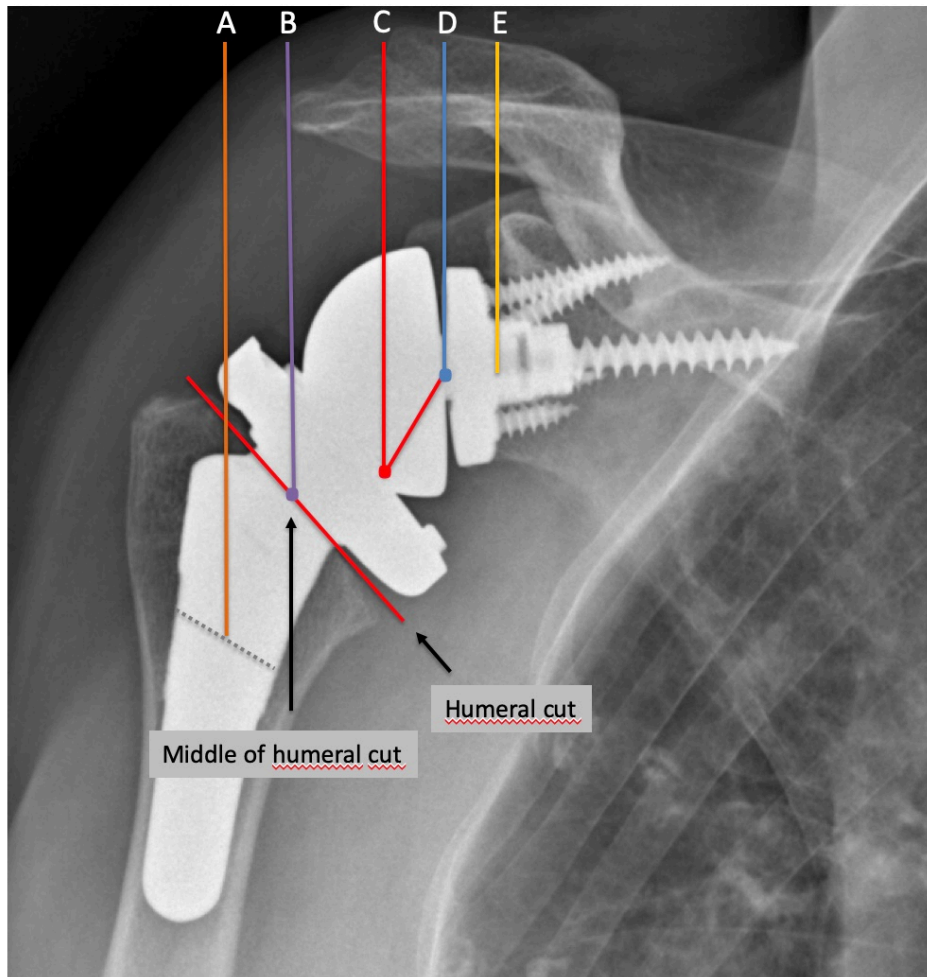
Radiographic references to measure humeral and glenoid offset in lateralized RSA (global lateral offset), as reported by Merolla et al¹³⁰ in line with the criteria described by Werthel et al¹⁵⁰. Line A is the vertical line passing through the middle of the diaphysis of the humeral stem. Line B is the horizontal line passing through the middle of the surface of the humeral implant at the level of the humeral cut. Line C is the vertical line passing through the “pivot point” defined as the deepest point of the articular surface of the humeral insert measured perpendicular to the surface of the humeral insert. Line D is the vertical line passing through the centre of rotation of the joint. Line E is the vertical line passing through the bone-glenoid baseplate interface. Humeral lateral offset (distance AC) was defined as the sum of the humeral stem offset (distance AB) and of the humeral insert offset (distance BC).
